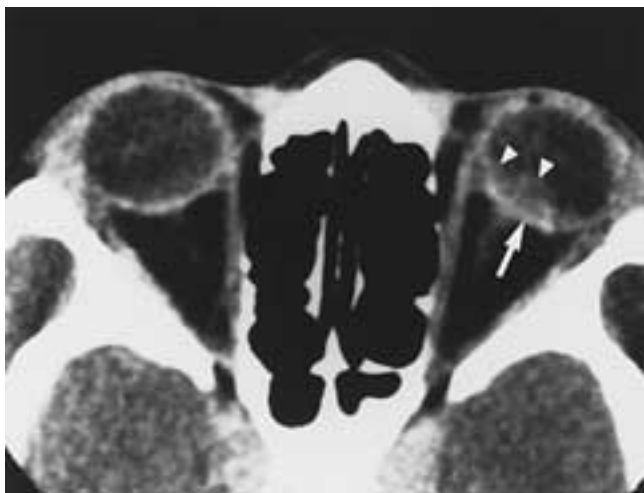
Ocular toxocariasis. Axial CT scan shows an irregular, moderately enhancing mass (arrowheads) with irregularity of the uveoscleral coat (arrow).
